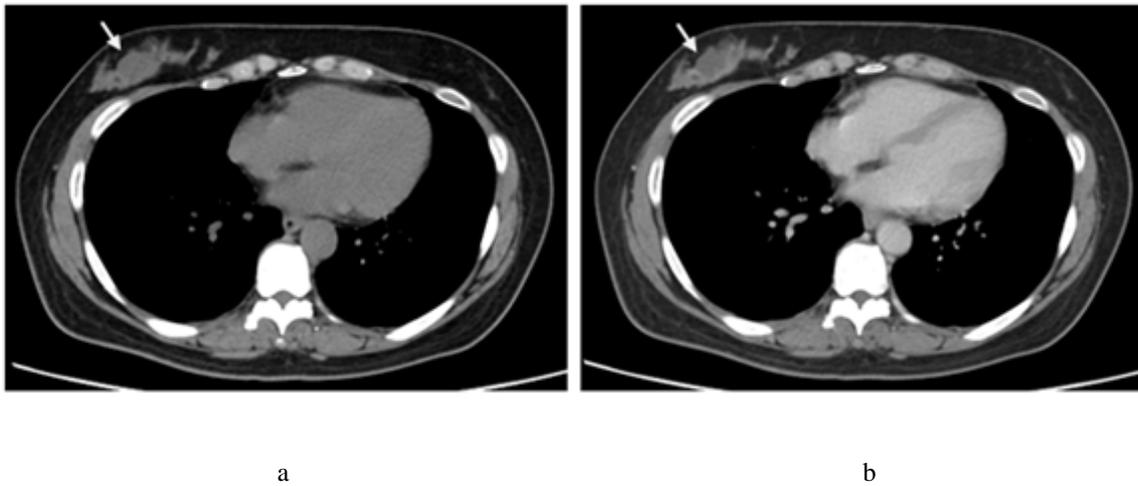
(a) and (b) Axial non-enhanced and contrast enhanced CT demonstrated circumscribed hypodense lesion (arrow) without enhancement in right breast (15 HU), likely cyst, BI-RADS 2.
